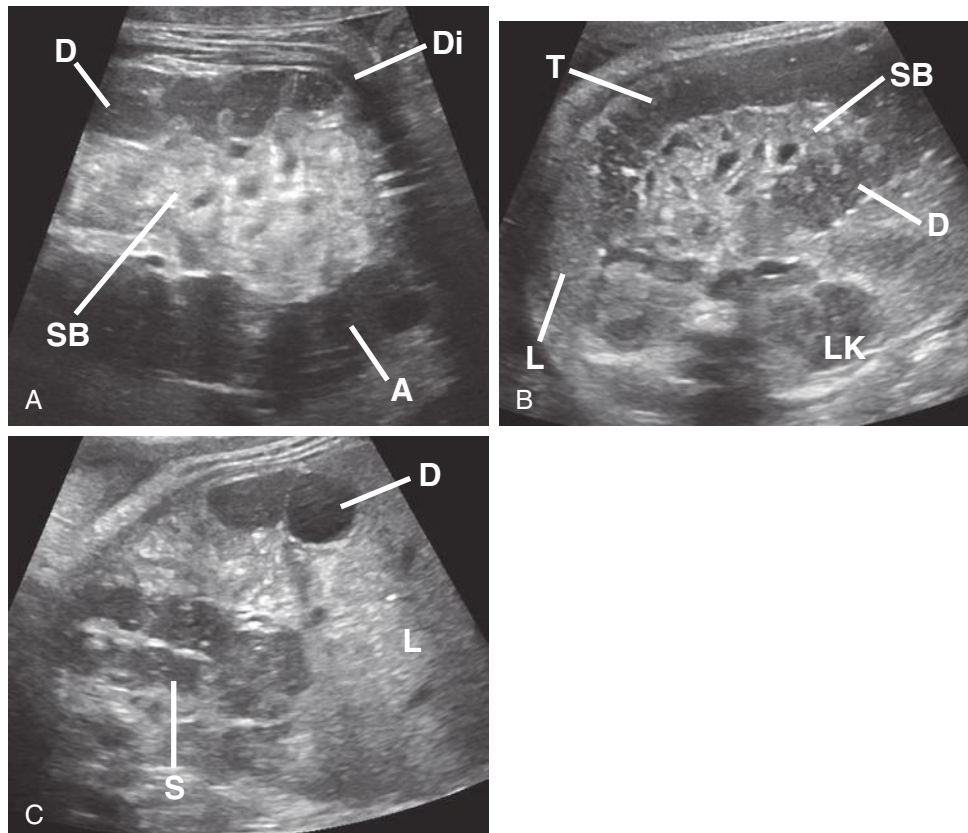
Coronal (A and C) and transverse (B) sonograms of the fetal abdomen demonstrating, by position, the ascending (A), transverse (T), descending (D), and sigmoid (S) colon. Di, diaphragm; L, liver; LK, left kidney; SB, small bowel.
